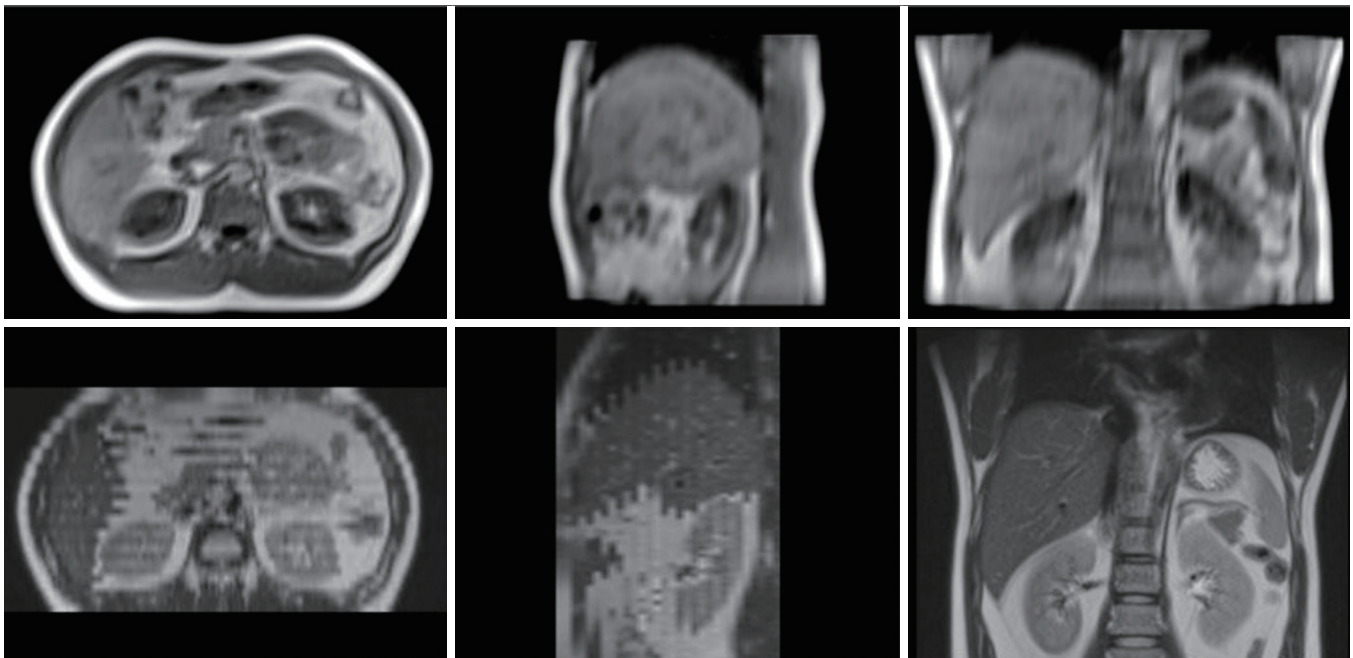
The reformatted CAIPIRINHA-VIBE 4D-MRI images (upper row) of a volunteer in comparison with the 2D-HASTE 4D-MRI images (lower row) in the same volunteer. CAIPIRINHA, controlled aliasing in parallel imaging results in higher acceleration; VIBE, volumetric interpolated breath-hold examination; HASTE, half-Fourier acquisition single-shot turbo spin-echo.
